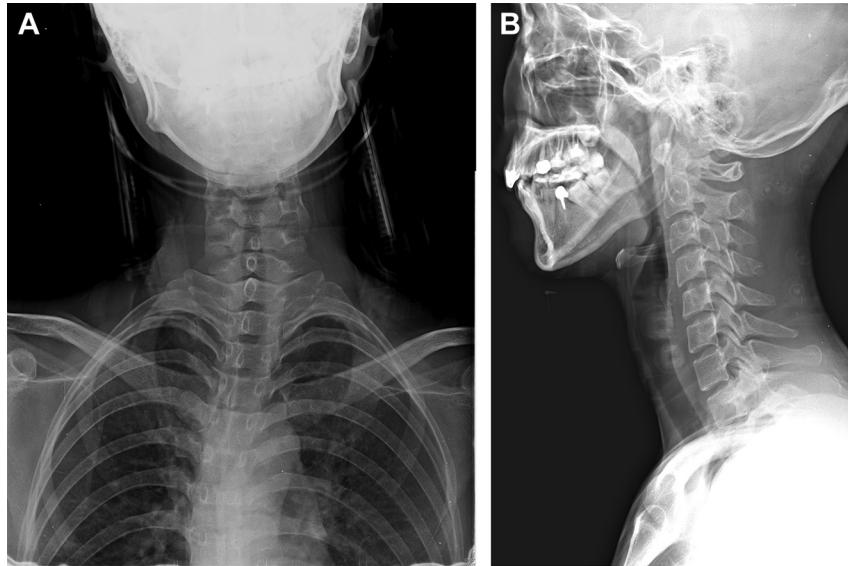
Cervical X-ray showed no fractures and the cervical spine alignment is normal. The patient wore a semi-rigid neck collar. (A) Anteroposterior view; (B) lateral view.
